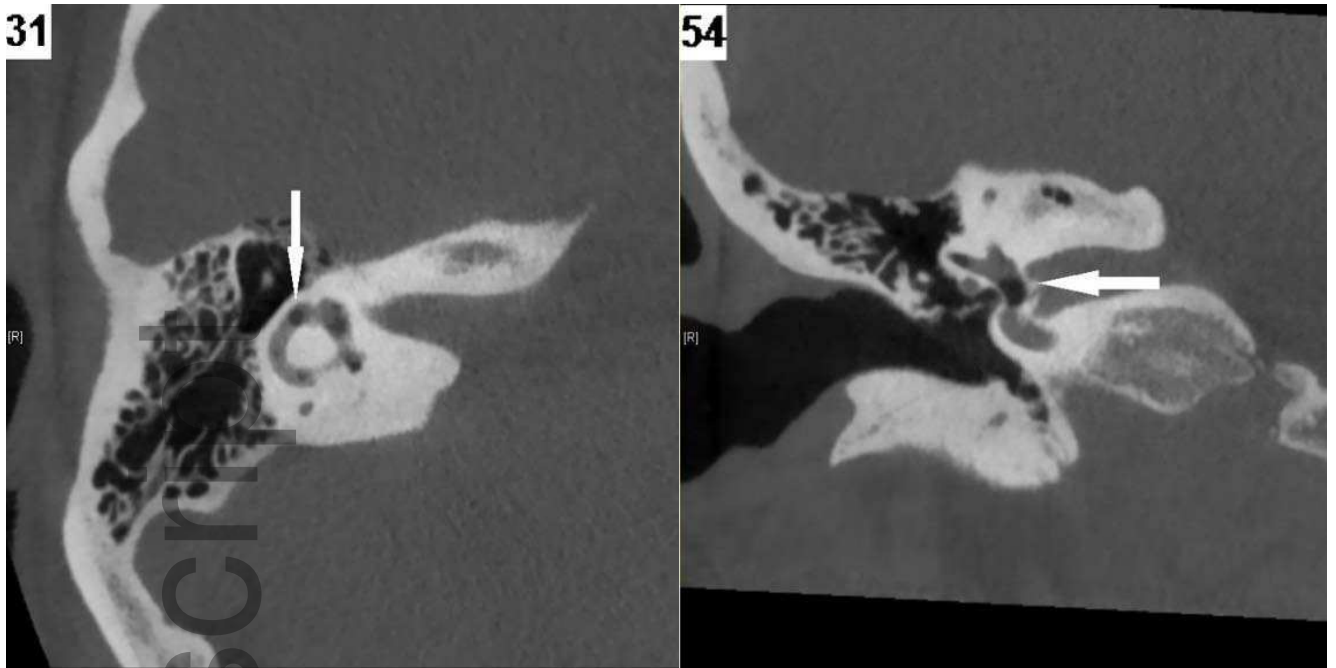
Case 3. Axial and coronal CT scans of patient with right PLF. Arrows point at pneumolabyrinth, seen in both the lateral semicircular canal (scan 31) and the vestibule (scan 54).
